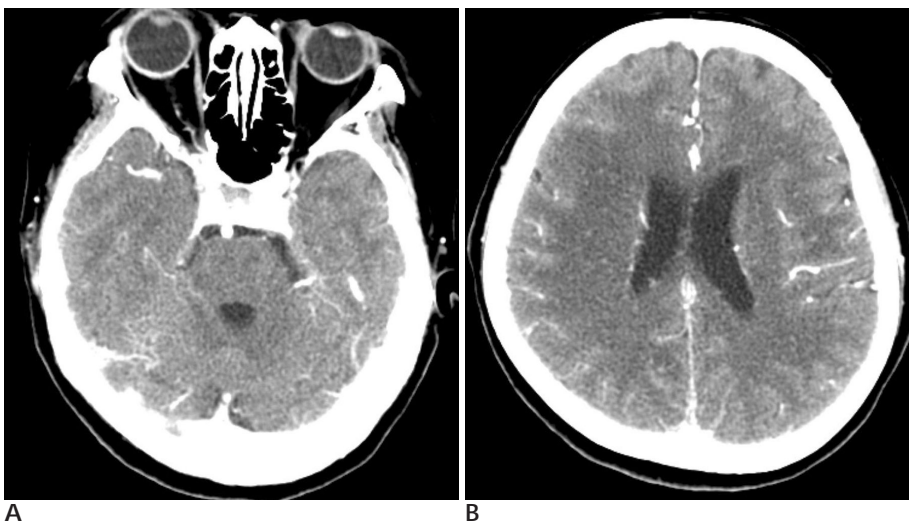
Follow up contrast-enhanced axial brain CT scans show decreased size and number of multiple enhancing nodules.
